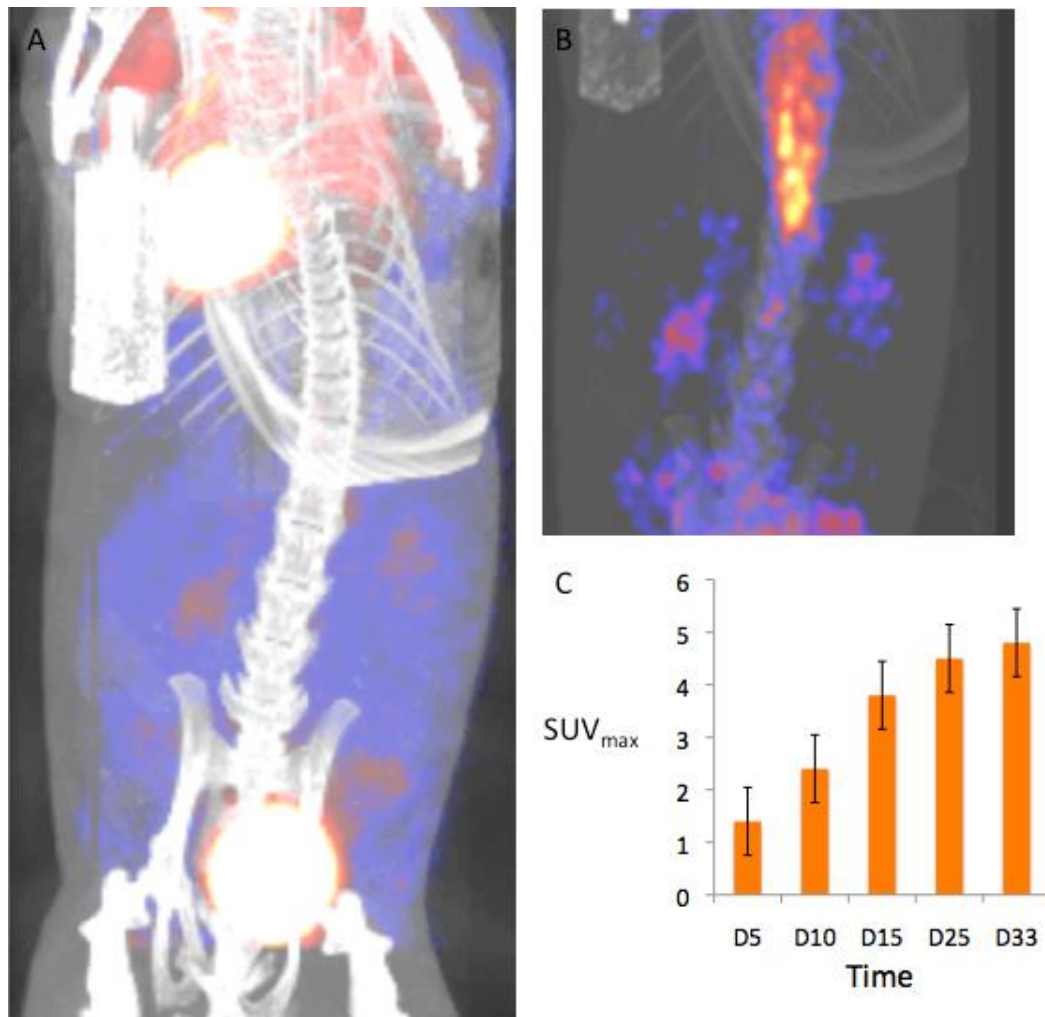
A fused PET-CT image, CT scout and ^{18}F -FDG uptake
